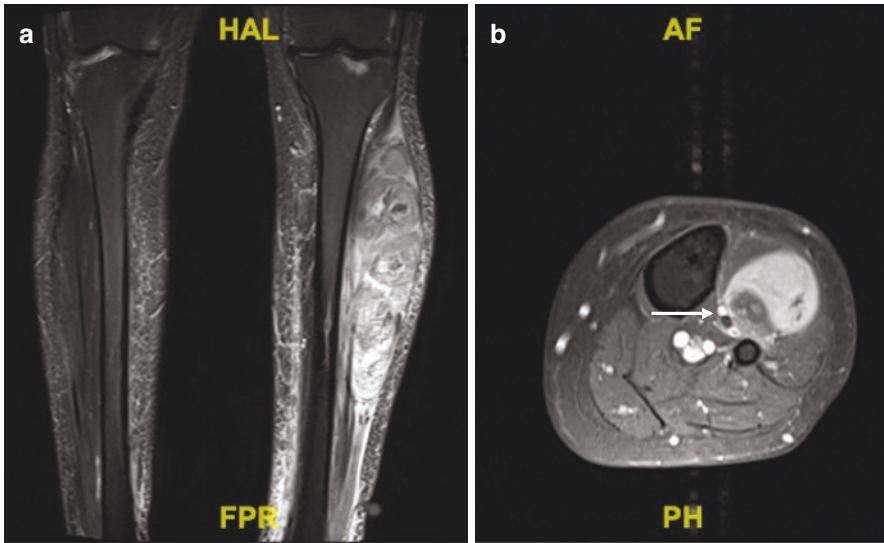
(a) Post-contrast coronal STIR and (b) axial T1-weighted fat-saturated MRI images of anterior lower leg undifferentiated pleomorphic sarcoma. Note proximity to anterior compartment neurovascular structures (arrow)
